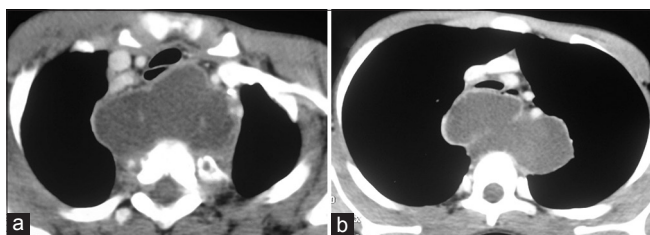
(a and b) Computed tomography (CT) of the chest depicting the cystic lesion posterior to the trachea
